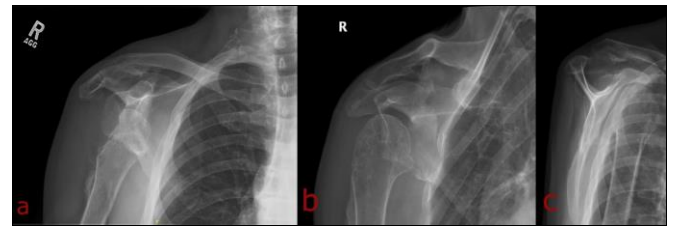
Right shoulder radiographs taken 5 weeks after attempted arthroscopic reconstruction, demonstrating a repeat anterior shoulder dislocation. Views: (a) anterior-posterior [AP], (b) Grashey, (c) Scapular-Y
